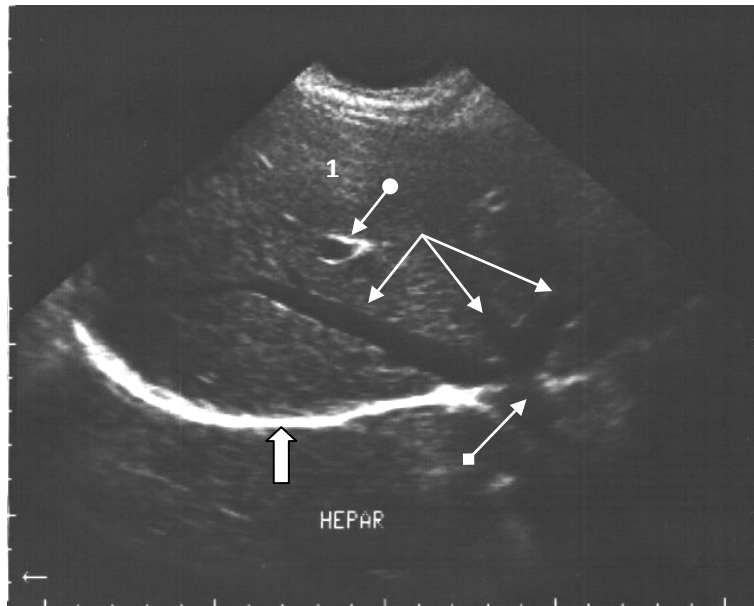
B – mode. Normal liver ultrasound. Longitudinal scan. Against parenchyma of liver (1), branches of the hepatic veins (white arrows) running into the vena cava inferior (arrow with rombus) are visible. Unlike hepatic veins vena portae hepatis has thicker and hyperechoic a walls (arrow with sphere). The diafragm produces the hyperechoic curved line posteriorly (figured arrow).
